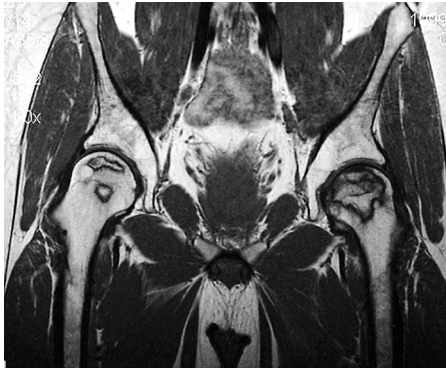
Avascular necrosis (AVN) of the hip. Coronal T1-weighted magnetic resonance image (MRI) through both hips confirms the presence of geographic areas of abnormality in both femoral heads which are well demarcated from the adjacent normal bone by a thin rim of low signal material. (From Adam A, et al. Grainger & Allison's diagnostic radiology. 5th ed. Edinburgh: Churchill Livingstone, 2008, Fig. 50-21.)
